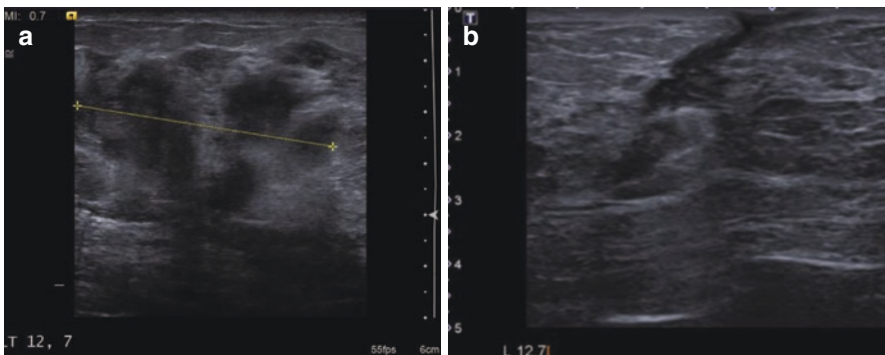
(a) Sequelae of granulomatous mastitis. A 32-year-old woman presenting with painful diffuse lump in the left breast. (b) Subsequent development of a sinus tract 8 months later. There is an ill-defined hypervascular microlobulated mass in the 12:00 position of the left breast on ultrasound. Core biopsy confirmed granulomatous mastitis
